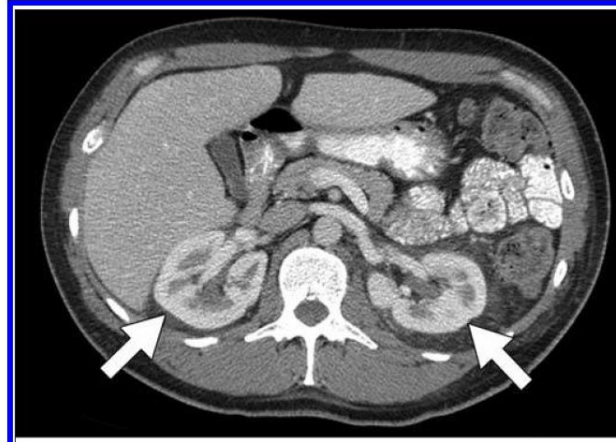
37-year-old man with melanoma. Contrast-enhanced CT scans show diffuse opacity of abdominal retroperitoneal fat (*arrows, top*) and pelvic fat (*large arrows, bottom*) and patchy haziness of subcutaneous fat (*small arrow, bottom*) after 16 months of anti-CTLA-4 treatment. Opacities progressed for 5 months and spontaneously regressed within 1 year with no steroid therapy.
